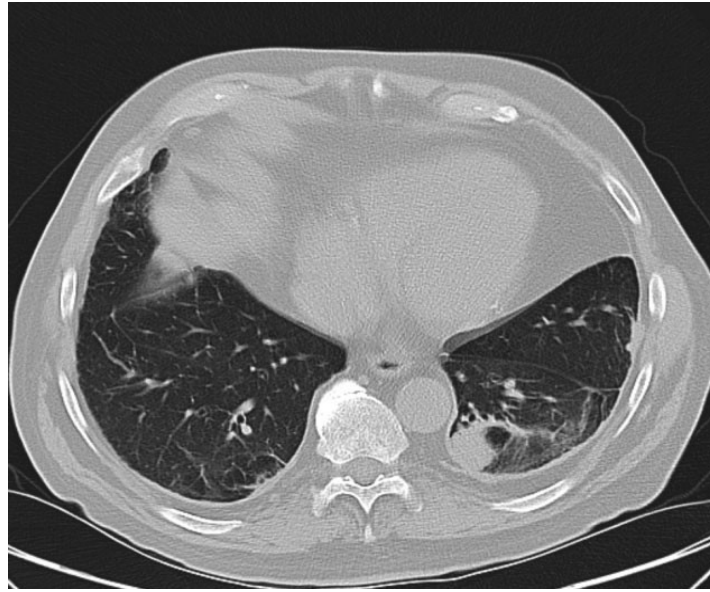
Computed tomography scan of the thorax demonstrating asbestos-related diffuse pleural thickening. Note the rounded atelectasis on the left and the sub-pleural interstitial pulmonary fibrosis bilaterally.
